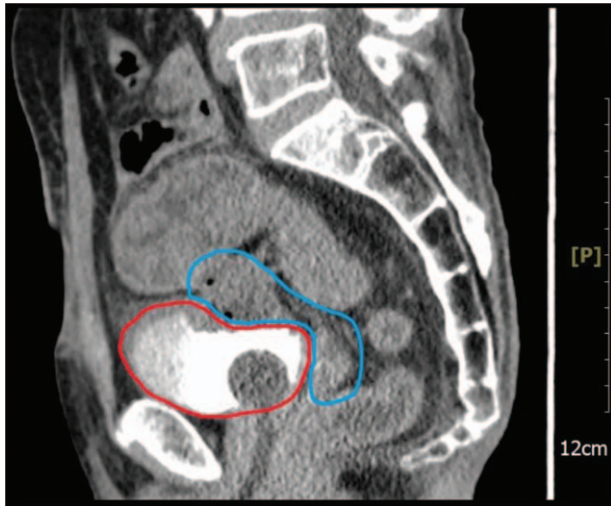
Sagittal abdominal computed tomography scan showing the tumoral mass (blue) adjacent to the rectosigmoid colon and urinary bladder (red).
